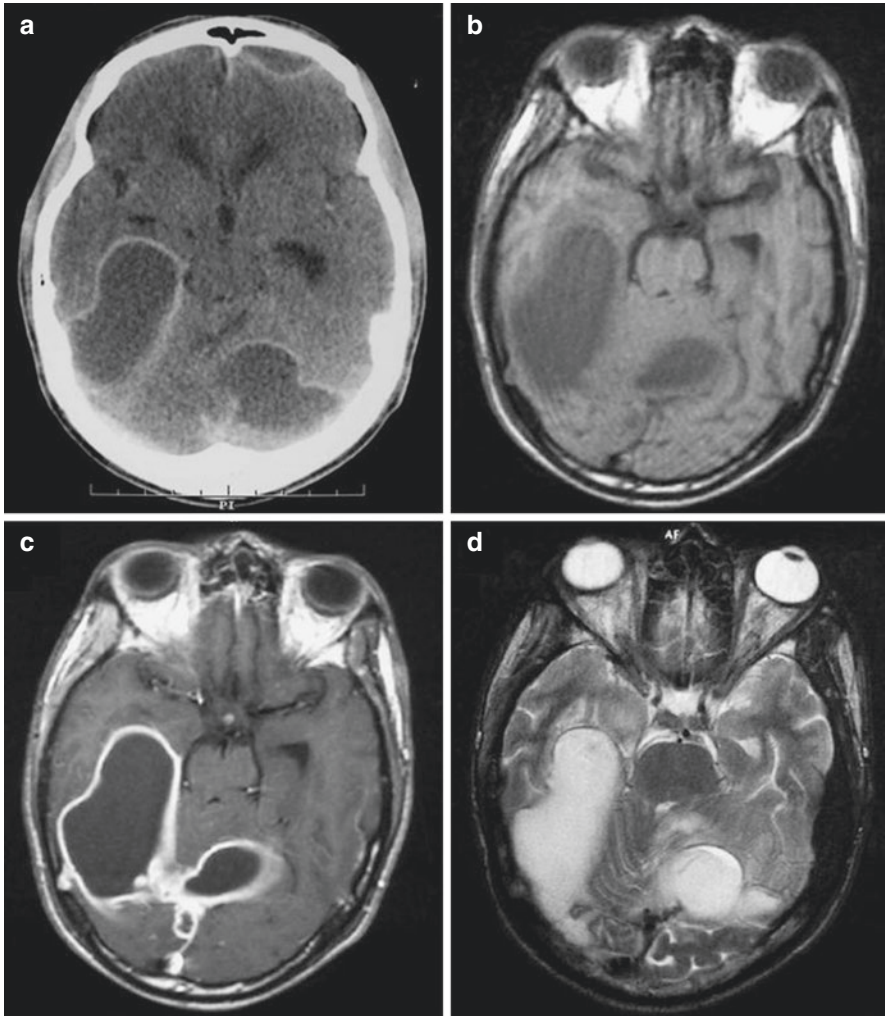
Case 6.4. Axial post-contrast CT scan (a). T1-weighted images without (b) and with (c) gadolinium injection, and a T2-weighted image (d) show multiple supratentorial (*right side*) and infratentorial (*left side*) subdural empyemas mimicking intraparenchymal brain abscesses
